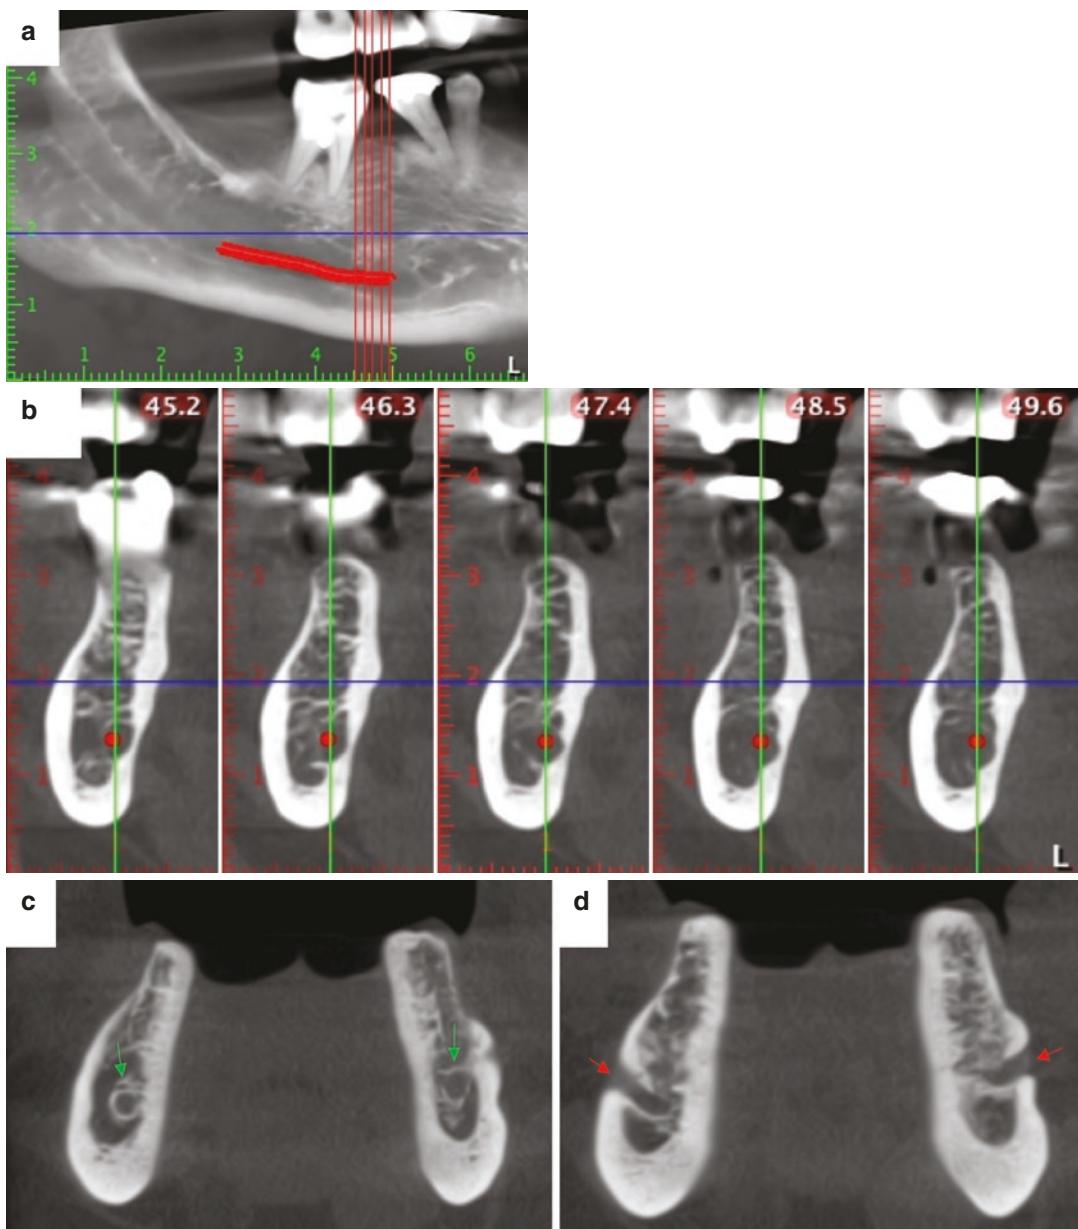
CBCT images produced for dental implant treatment planning. (a) reconstructed panoramic and (b) cross-sectional views. Inferior alveolar nerve marking is also
